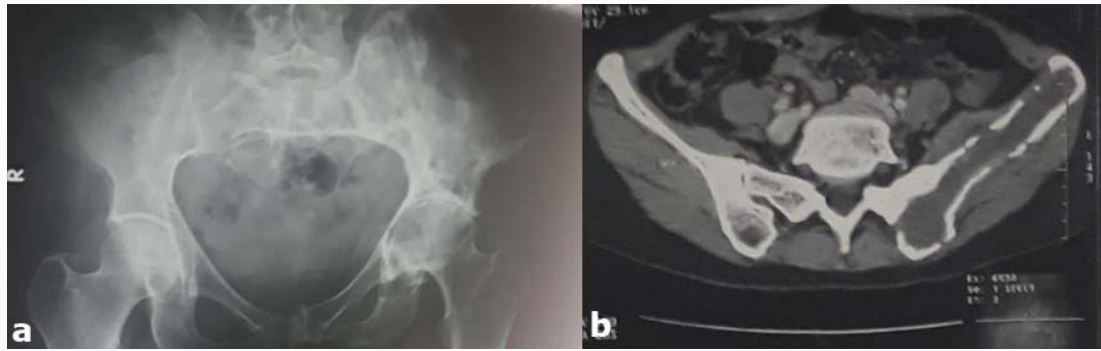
Left iliac bone hydatid cyst (a: X-rays, b: CT scan).
